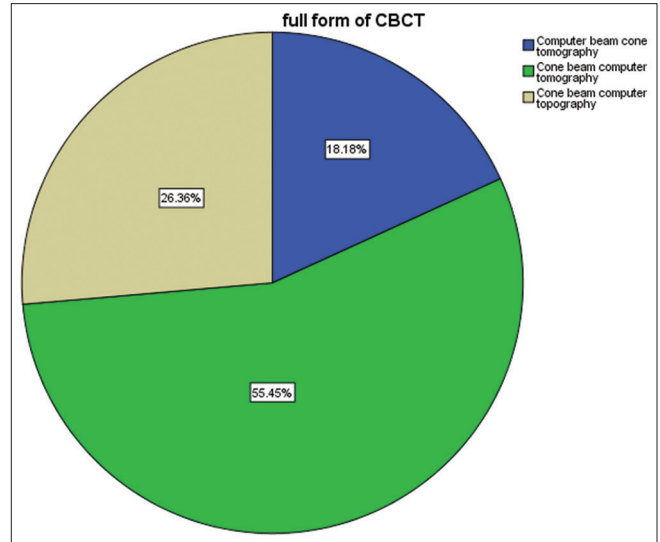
The cone-beam computed tomography full form which has answered by students
